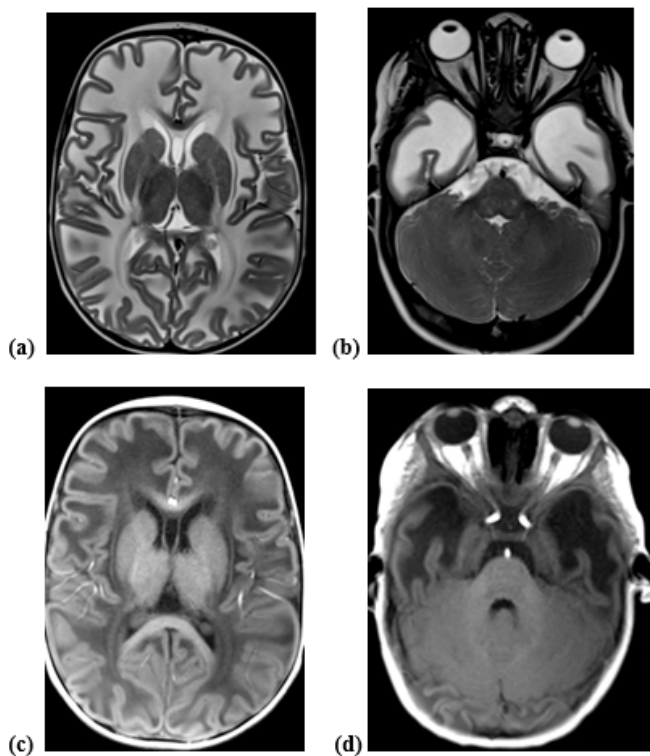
MRI axial sections in T2 (a and b) and T1 (c and d) weighted sequences. Diffuse supratentorial leukodystrophy in hypersignal and predominantly in the fronto-parietal and temporal regions. Integrity of basal ganglia and subtentorial white matter.
